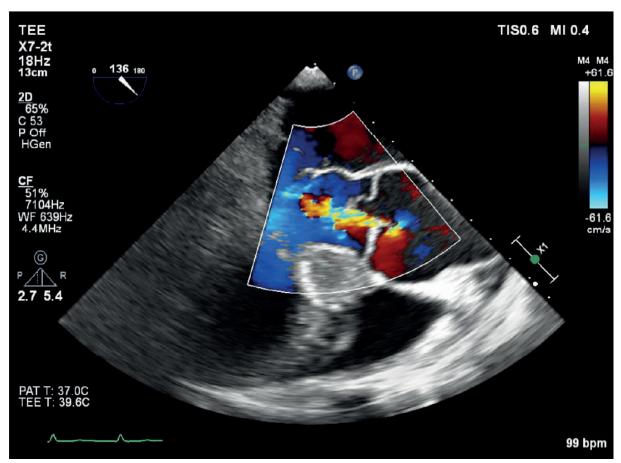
Transesophageal echocardiography with color Doppler showing grade two aortic regurgitation.
